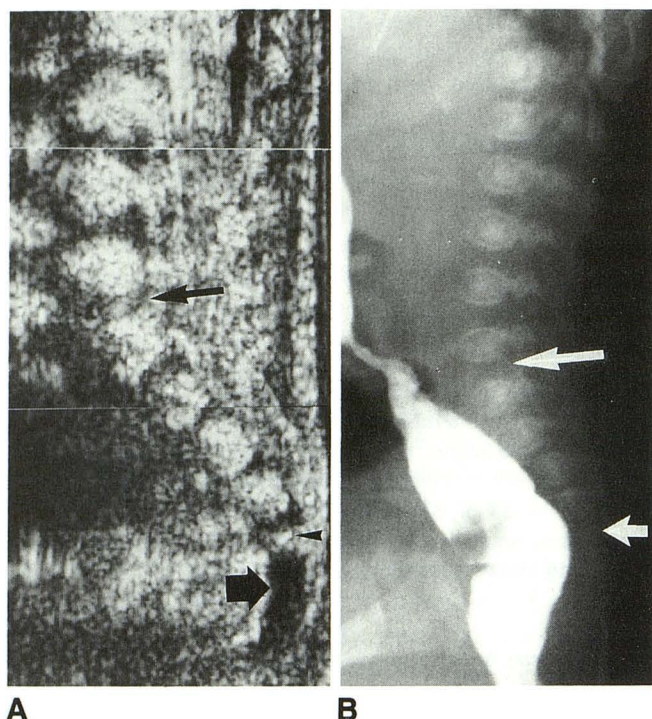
(A) Composition sonogram of the lower spine. The LSJ is shown as a lordotic transition (*long arrow*) between the lumbar and sacral vertebrae. The fifth sacral body ossification center is visible (*arrowhead*). The coccyx is composed of hypoechoic cartilage (*short arrow*).
